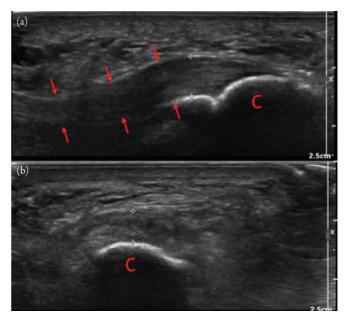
Plantar fasciitis on ultrasound. Grayscale sonographic images in longitudinal (a) and transverse (a) plane of the proximal plantar fascia near its calcaneal origin in the proximal plantar aspect of the hindfoot. Thickening and hypoechogenicity of the plantar fascia noted. The key anatomic landmark of the calcaneus (C) is shown.
